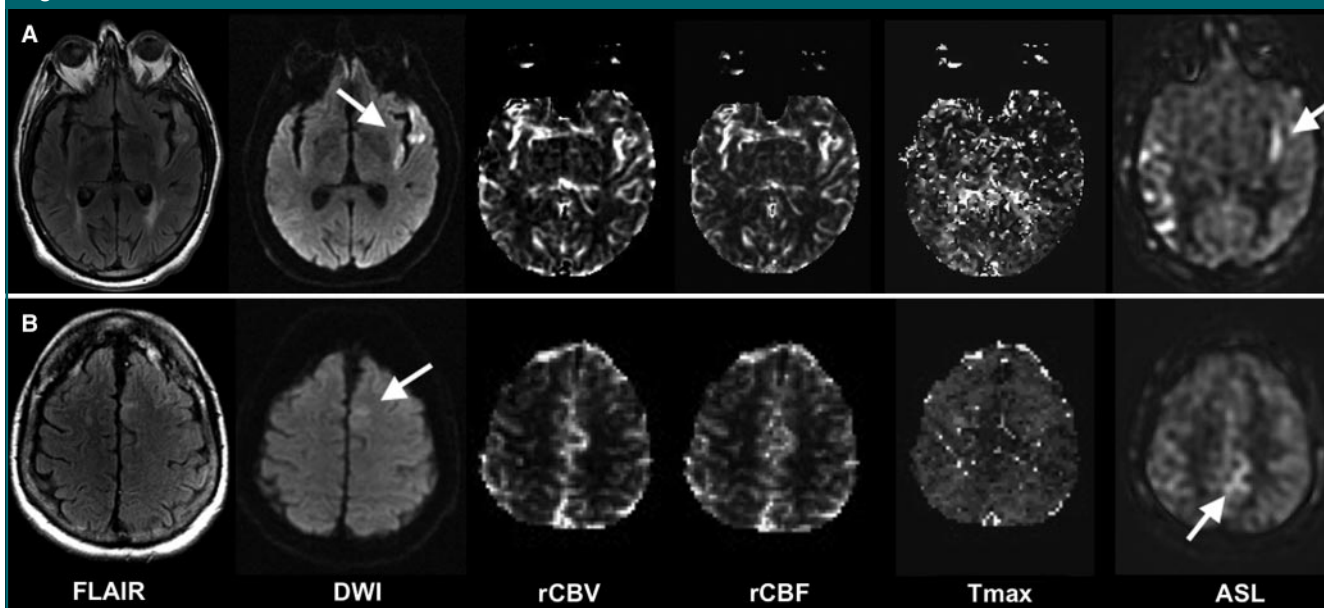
Fluid-attenuated inversion-recovery (FLAIR) (8802/110/2200), diffusion-weighted (DWI) (6000/70, $b = 1000$ sec/mm²), and ASL images, and relative cerebral blood volume (rCBV), relative CBF (rCBF), and normalized time to peak of the residue function (Tmax) maps (1225/17, 30, 52) obtained in two patients with linear high ASL signal near brain regions with reduced diffusion. Both patients had normal bolus PW imaging findings. *A*, Imaging findings in 76-year-old man 3 days after acute onset of aphasia, right-side weakness, and visual disturbance. Diffusion-weighted image shows positive lesions (arrow) in and around left insula. ASL image shows linear increased signal intensity (arrow) in left insula; this lesion possibly represents slow blood flow or recanalization. *B*, Imaging findings in 77-year-old woman with difficulty rising from a chair. On diffusion-weighted image, the region of focal diffusion abnormality (arrow) in left anterior cerebral artery territory is subtle but was thought to represent early infarction. On ASL image, the linear high signal (arrow) in area immediately posterior to diffusion abnormality may represent slow antegrade arterial or collateral blood flow.
